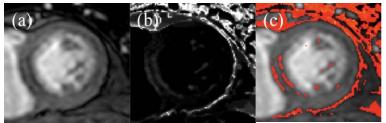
(a) Short-axis gradient-echo image at Td=19s showing a dark rim artefact. (b) Magnitude image from SGM of the gradient-echo data corresponding to (a). (c) Threshold of SGM in (b) to show shifts greater than 4 pixels overlaid in red onto image data. Again at Td=15 and 22s, a line of hyper-intensity is observed gradient-echo MR image to highlight location of suspicious susceptibility gradients
